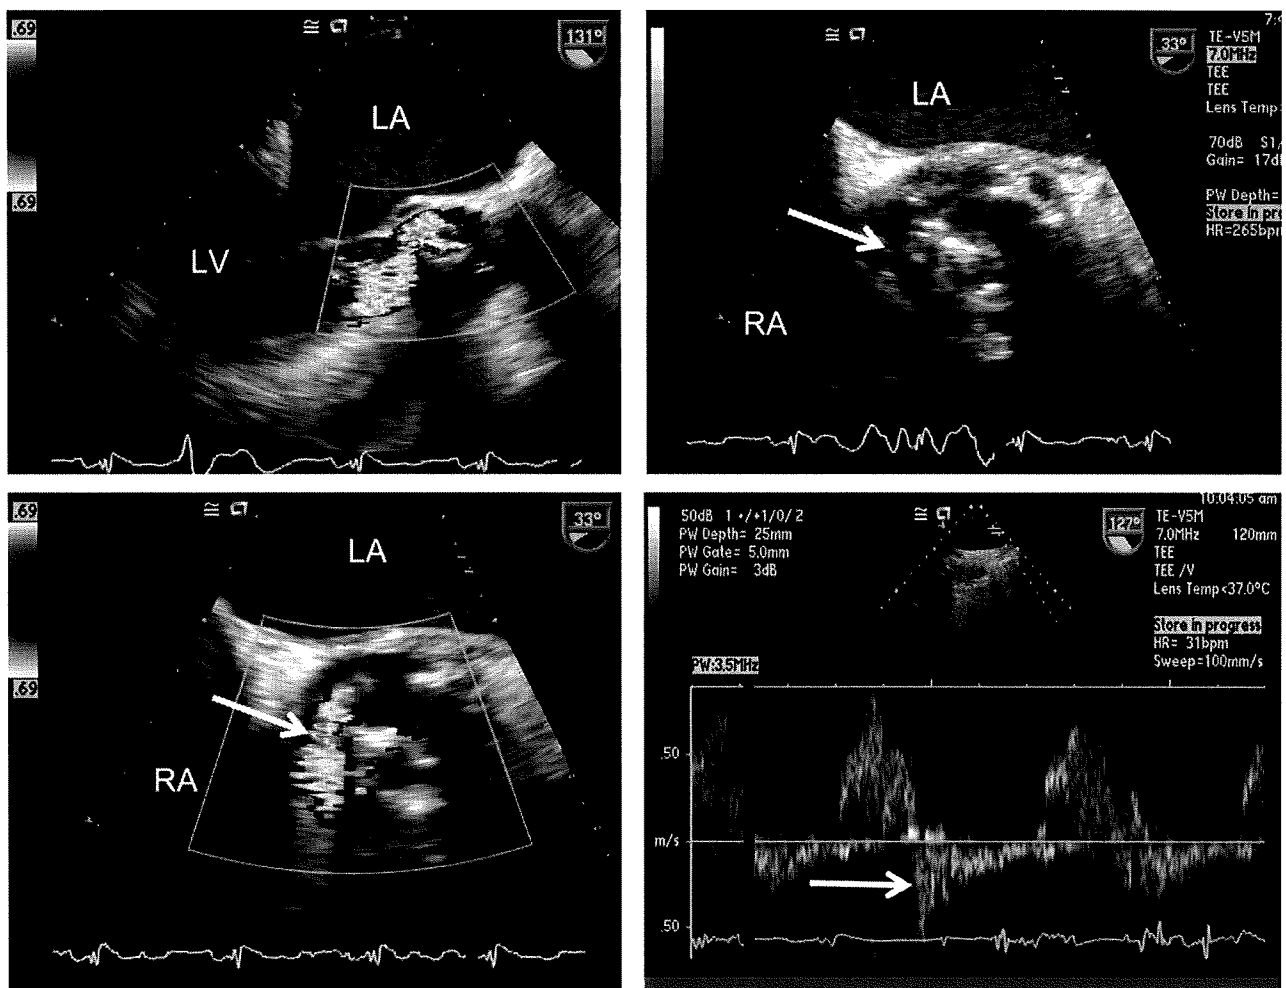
Transesophageal images of a patient with perivalvular significant AR demonstrating (arrows) the extent of dehiscence and regurgitation in cross-section and diastolic flow reversal in the descending aorta. Flow convergence in the aortic root, vena contracta, and an eccentric jet directed anteriorly in the LVO toward the septum (left upper panel) are seen. Because of jet eccentricity, measurement of jet width to LVO diameter is not advised in this case. See Videos 11 and 12. [View video clips online.](#)
